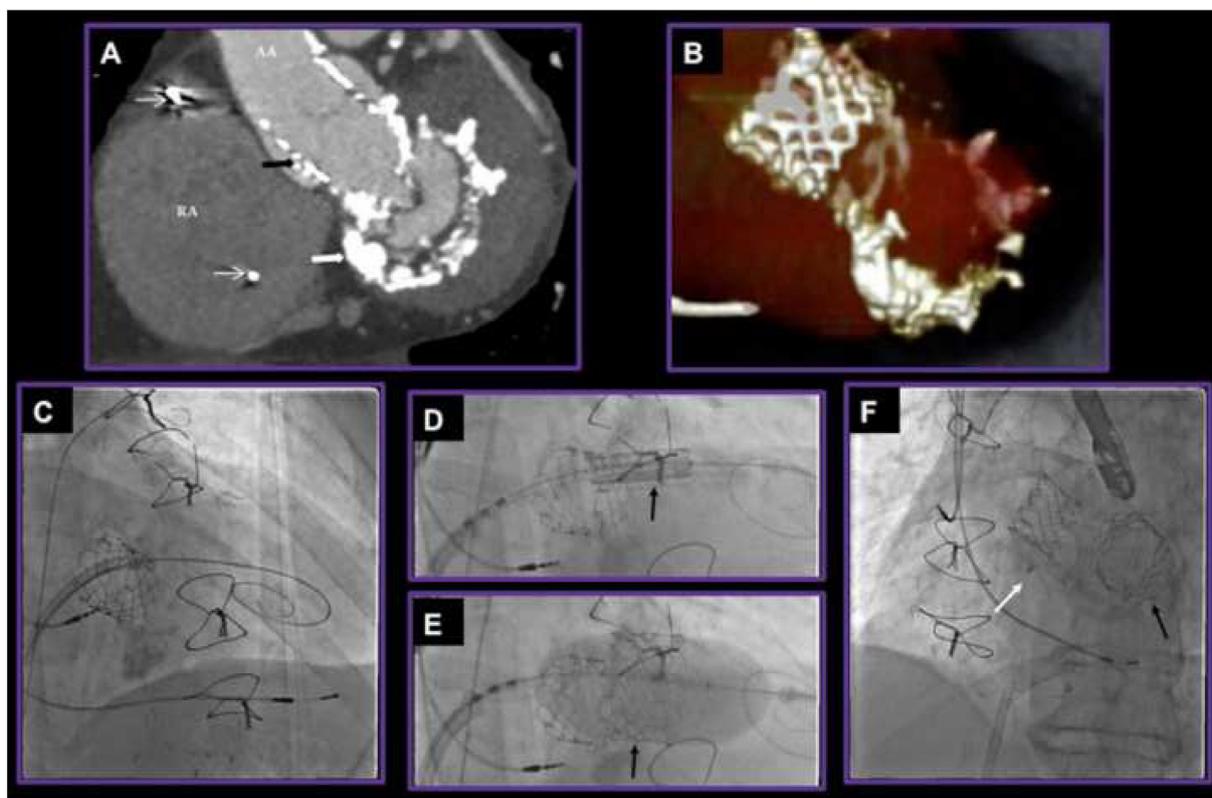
A. Pre-procedure CT Coronal reformat demonstrates the TAVR in aortic position (black block arrow) and the dense calcification in the mitral annulus (white block arrow). Also note the presence of pacemaker lead (thin white arrows) in the right atrium (RA). AA: Ascending Aorta. B. Pre-procedure 3D CT coronary reconstruction demonstrating TAVR in aortic position and heavy ring of calcium around mitral annulus. C. Fluoroscopy of transseptal puncture using an Agilis Steerable Sheath with Safari wire in the left ventricle and Amplatzer Support Wire in the pulmonary artery to support valve deployment. D. Fluoroscopy of 29 mm Edwards SAPIEN 3 aortic THV prosthesis positioned in calcified mitral annular ring (Black arrow). E. Fluoroscopy of 29 mm Edwards SAPIEN 3 aortic THV prosthesis deployed within calcified mitral annular ring (Black Arrow). F. Fluoroscopy of deployed TMVR (black arrow). ASD closure device (visible next to TAVR) deployed (white arrow).
